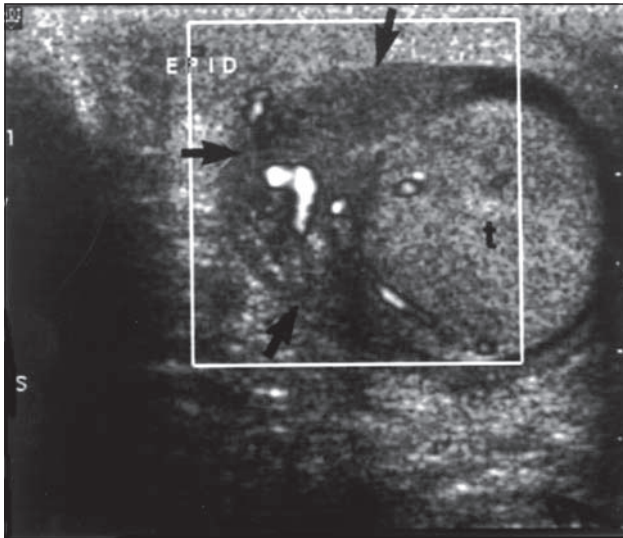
Epididymitis (transverse view). Color Doppler shows increased flow in enlarged epididymis (arrows). T = testis.
